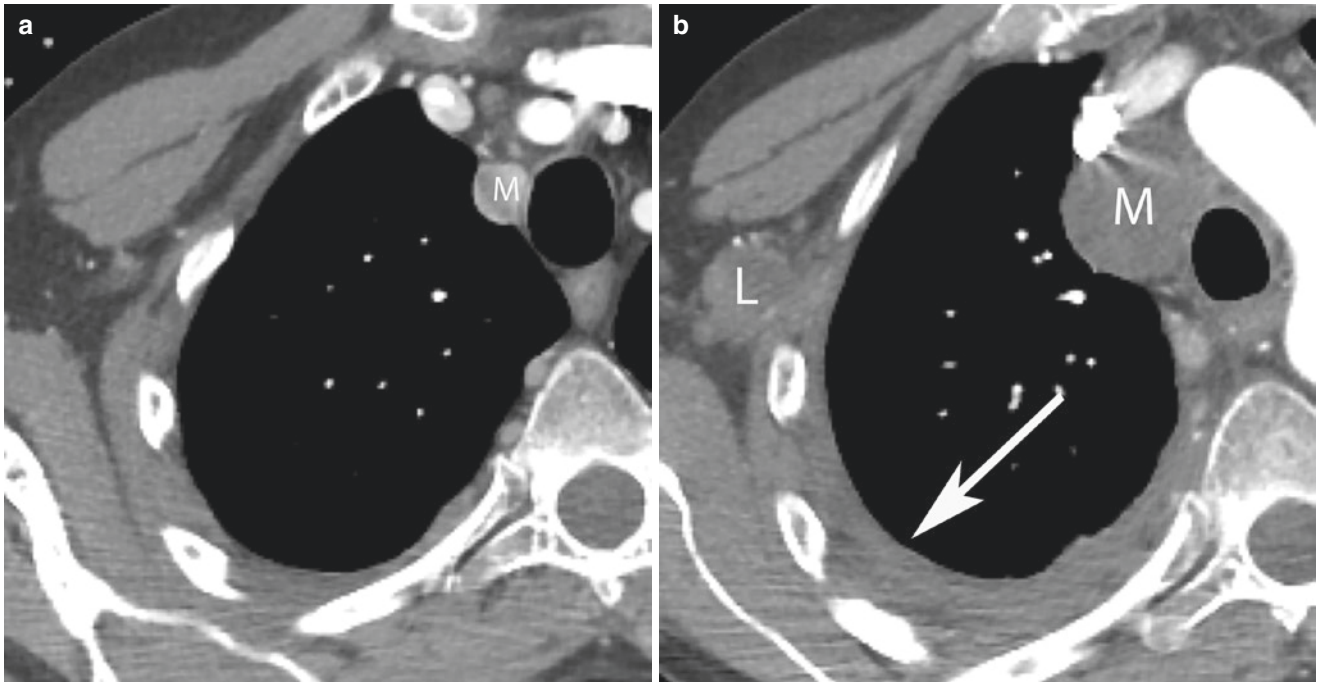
Primitive neuroectodermal tumor (PNET). (a) Contrast-enhanced axial CT shows a small heterogeneously enhancing right paratracheal pleural nodule (M), (b) contrast-enhanced axial CT
